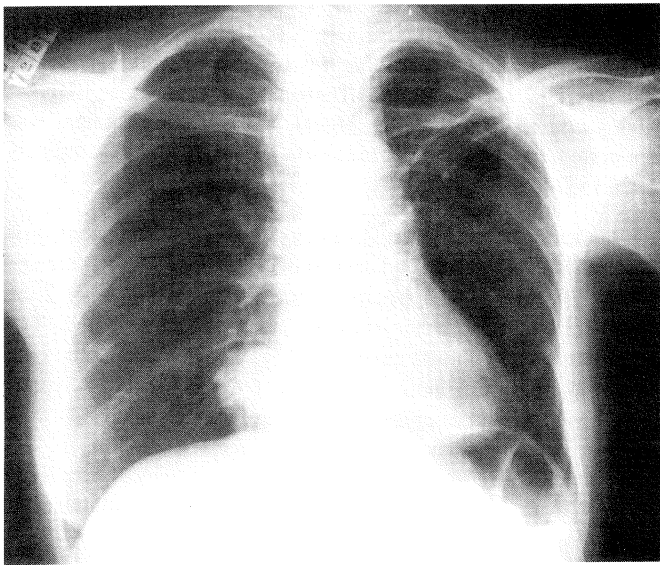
Chest X-ray in October 1986. Note spontaneous resolution of the upper lobe infiltrate. Appeared two nodular images in the right lung: perihilar mass (3 x 4 cm) and a nodule (0.8 cm) in the projection of the posterior arc of the eighth rib.
